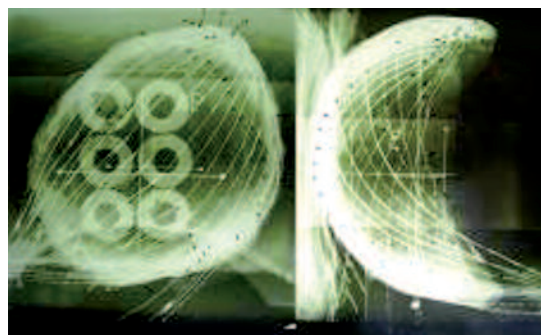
2 orthogonal x-ray
